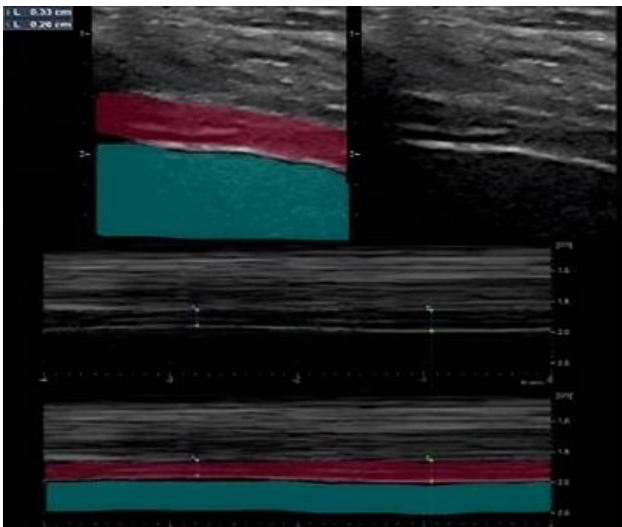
Ultrasound performed after application of TMP (rapid shallow breathing index & diaphragmatic thickening fraction observed by t1-weighted ultrasonography by M-mode [highlighted in red-diaphragm muscle & blue-liver]) (Source: Authors' own elaboration)
